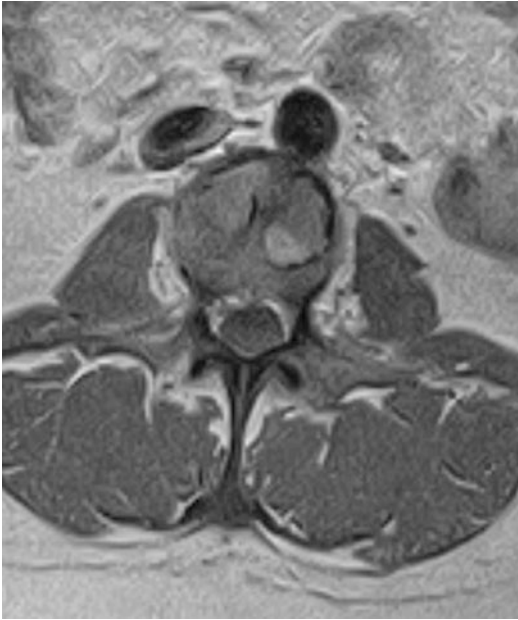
The axial T1 post-gadolinium MRI of the tumor at the time of presentation
